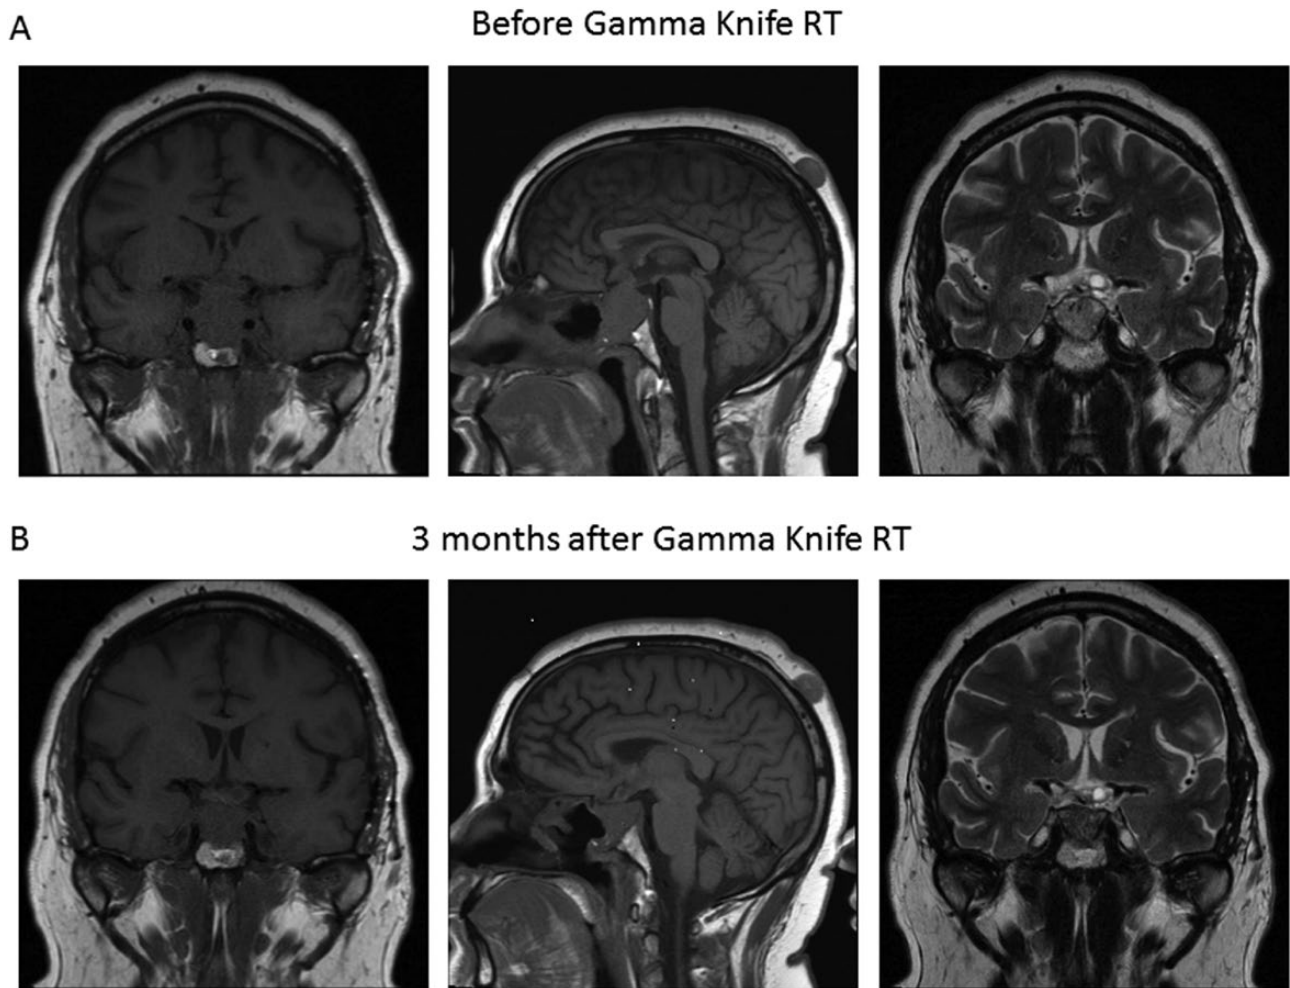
MRI scans before and after gamma knife radiotherapy. A: MRI scans demonstrating a gradual enlargement of a cystic component in the area of the optic chiasm while on a 50% dose of vemurafenib. B: MRI scans 3 months after gamma knife radiotherapy that showed a reduction in size of the cystic component as well as the residual papillary craniopharyngioma. Abbreviations: MRI, Magnetic resonance imaging; RT, radiotherapy.
